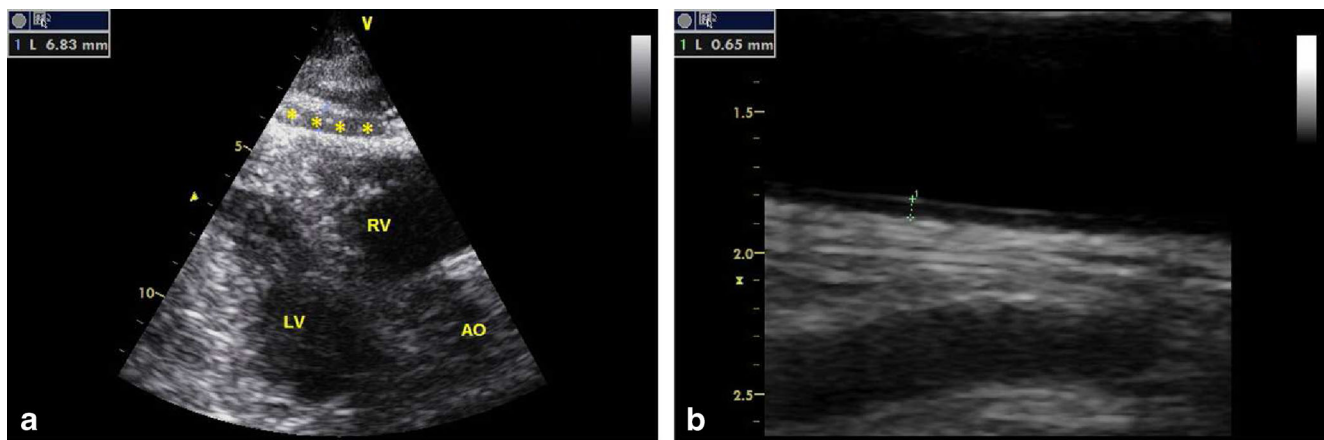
The demonstration of a) epicardial fat tissue (asterisk signs) on parasternal long-axis view of transthoracic echocardiography and b) carotid artery intima media thickness measurement on high-resolution B-mode ultrasound
